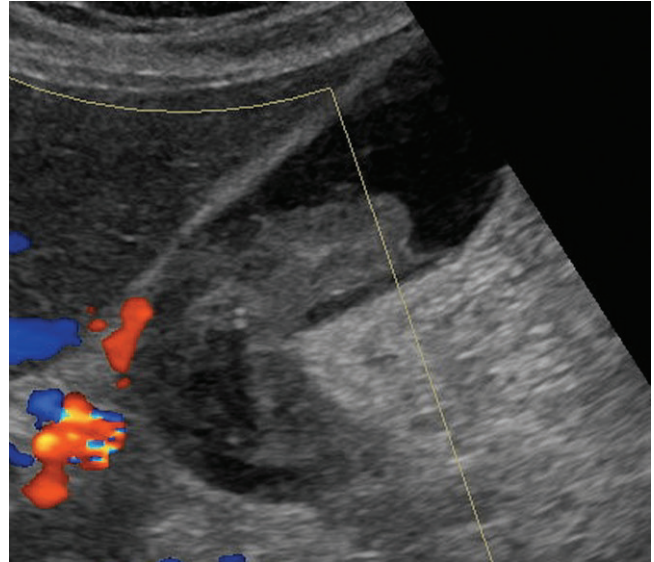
Doppler evaluation does not demonstrate internal vascularity.
